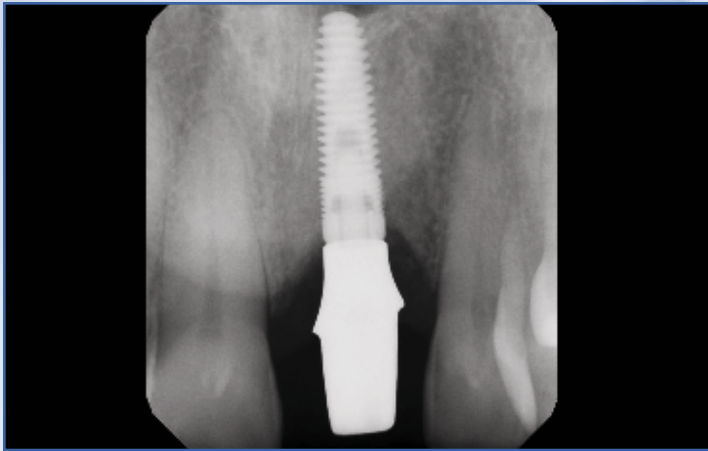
A radiograph was taken to verify complete seating of the prepared abutment.
